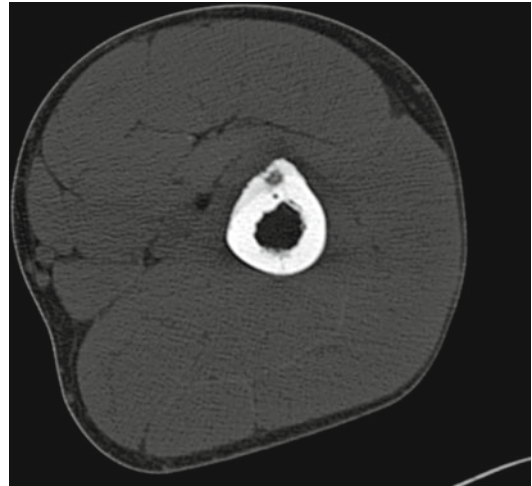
CT-guided placement of an RF probe in a patient suffering from osteoid osteoma of the femur. Corresponding to conventional radiography, the unenhanced CT scan reveals the thickening of the cortical bone with the centrally located nidus
